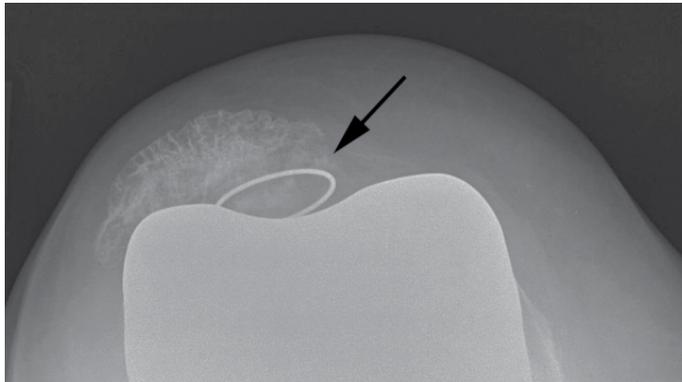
Prosthetic Button Loosening. A 71-year-old woman, two years after total knee replacement. Axial radiograph (Merchant view) shows patellar subluxation with prosthetic button loosening (arrow).
